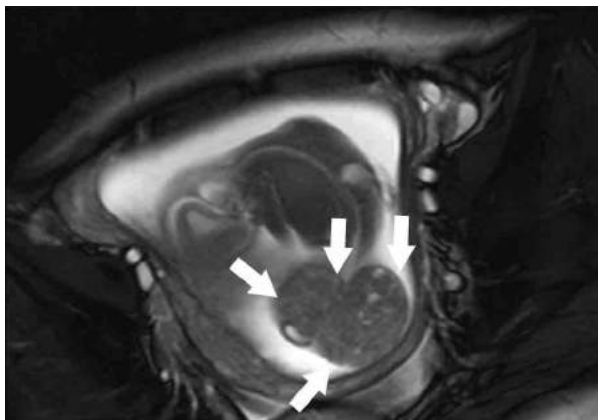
Fetal MR imaging at 20 weeks with type I sacrococcygeal teratoma. Coronal T2-weighted trufi HQ MR image (TR 214.1ms, TE 1.76ms) shows large caudal extrapelvic mass (arrows) in sacrococcygeal region
